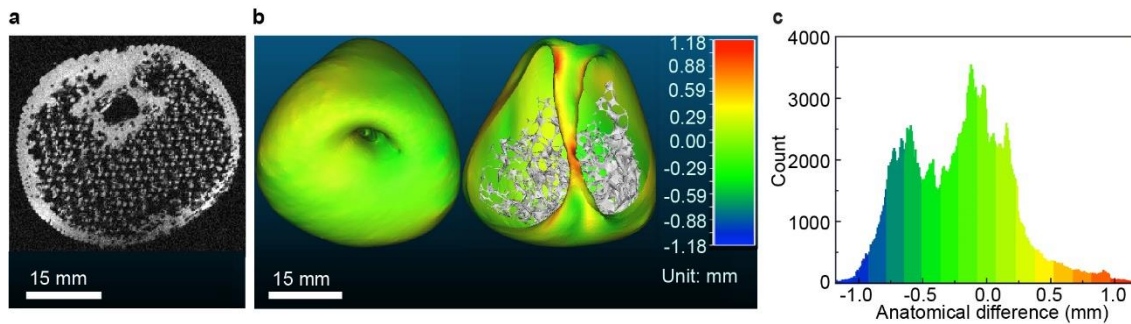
Anatomical fidelity analysis of the 3D printed model in comparison with patient’s prostate. (a) An MRI image obtained via scanning a 3D printed prostate model. (b) Calibrated distance map obtained via 3D registration for comparison of anatomical fidelity between patient prostate and 3D printed prostate model at the outer surface (left) and urethra surface (right). (c) Histogram of the calibrated distances of the surface points for comparison of anatomical fidelity between patient prostate and 3D printed prostate model.
